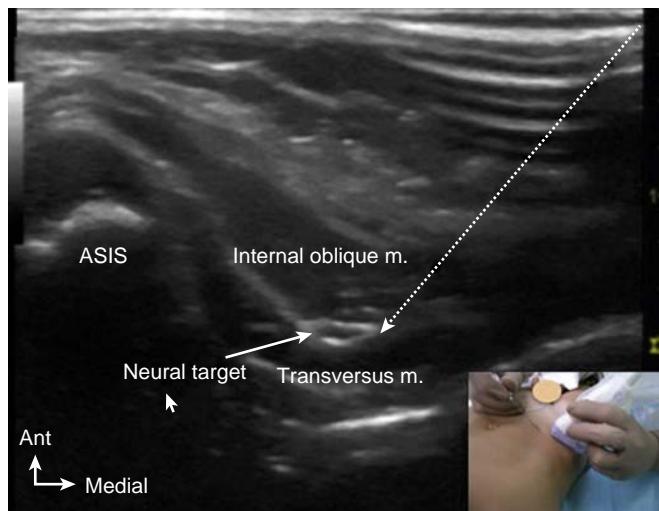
Ultrasound. Ilioinguinal and iliohypogastric block imaging and probe placement for in-plane needle insertion. ASIS, Anterior superior iliac spine; m, muscle.
